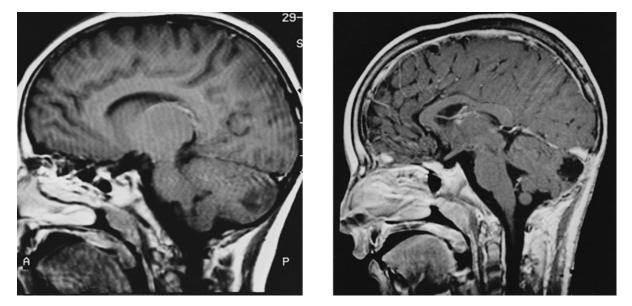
T_1 -weighted sagittal MRI: pre-operative showing an astrocytoma of the posterior left cerebellar hemisphere (*left panel*) and post-operative showing the site and extent of excision (*right panel*).
